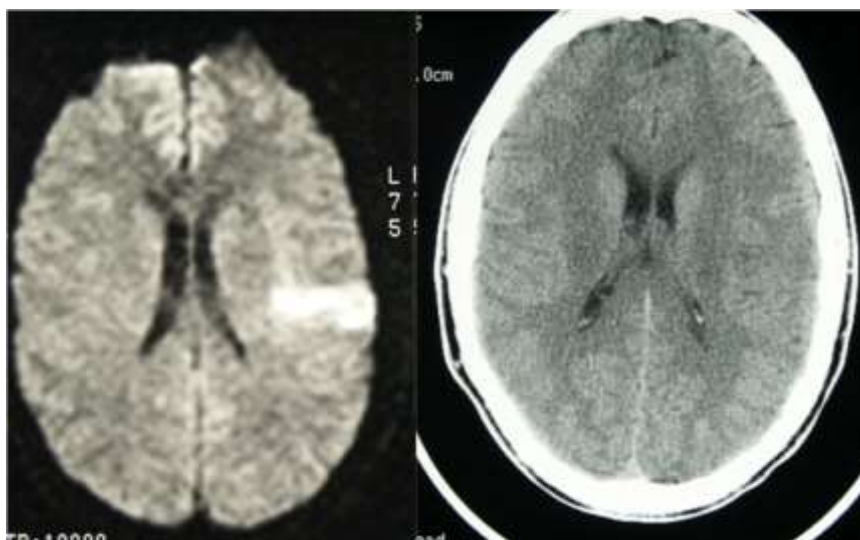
DWI is the most powerful method to reveal cerebral ischaemia. In the left of the image, DWI reveals an area of signal hyperintensity in the left frontal lobe corresponding to the cytotoxic oedema during the hyperacute phase of stroke, when CT scan (in the right side of the image) is still unremarkable.
